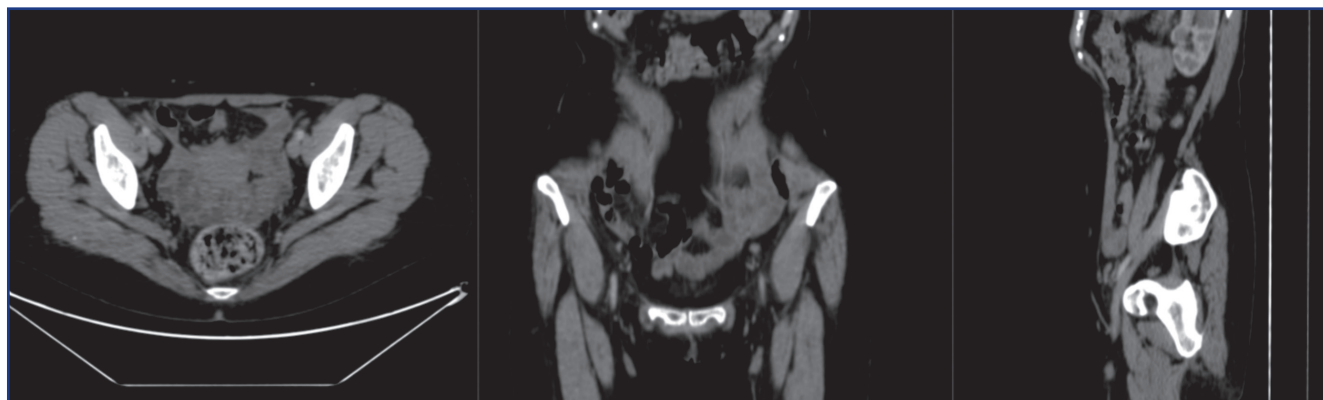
CT of the chest, abdomen and pelvis with intravenous contrast on July 22, 2022
